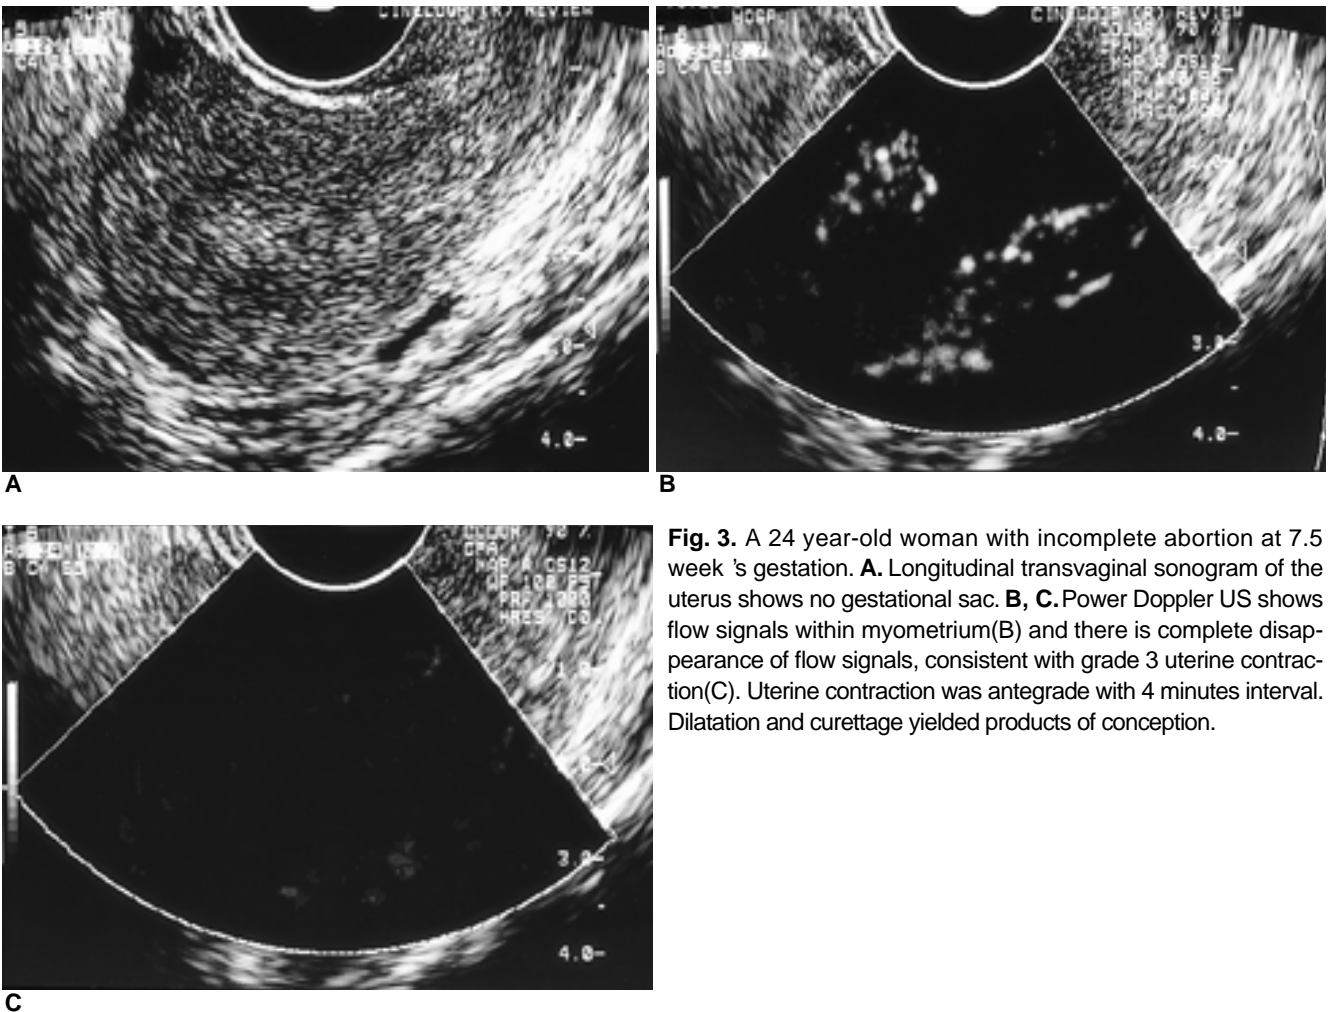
A 24 year-old woman with incomplete abortion at 7.5 week's gestation. A. Longitudinal transvaginal sonogram of the uterus shows no gestational sac. B, C. Power Doppler US shows flow signals within myometrium(B) and there is complete disappearance of flow signals, consistent with grade 3 uterine contraction(C). Uterine contraction was antegrade with 4 minutes interval. Dilatation and curettage yielded products of conception.
